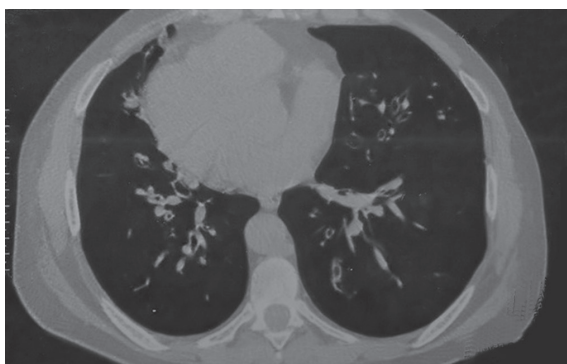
Air trapping and bronchiectasis in a lung high-resolution computed tomography of a mustard gas-exposed case, 25 years post exposure, consistent with bronchiolitis obliterans. (from the private collection of the corresponding author)
